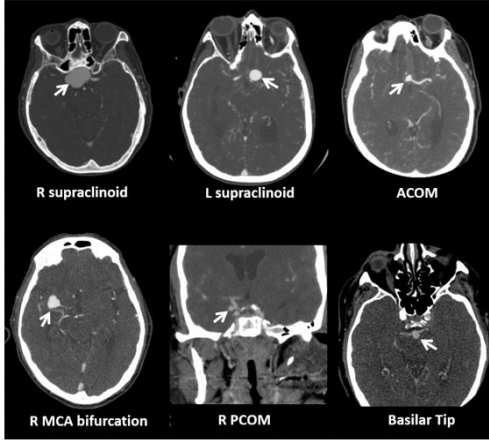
Examples of aneurysms detected by CTA scans; aneurysms are labelled with white arrows
